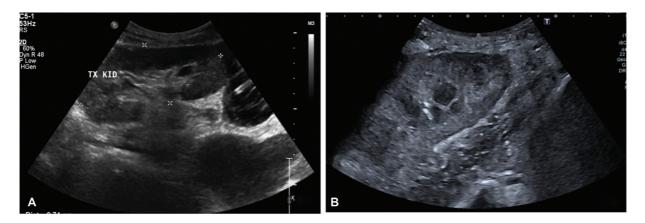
A 25-year-old male patient with postrenal transplant status presented with lymphocele. Follow-up ultrasound (A) at 1 week postballoon fenestration shows persistence of the lymphocele (*white arrow*) and (B) at 1 month postballoon fenestration reveals resolution of the lymphocele.
